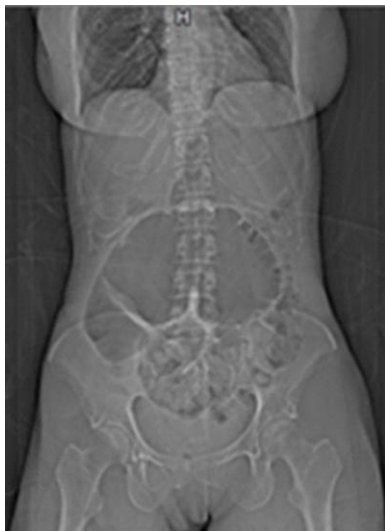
A 50-year woman CT scan: coffee bean sign
